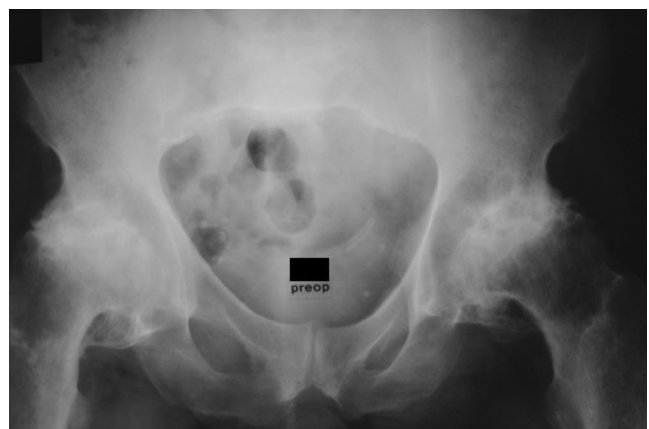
Anterior-posterior pelvic radiograph demonstrating severe hypertrophic osteoarthritis in bilateral hip joints with marked joint degeneration.
